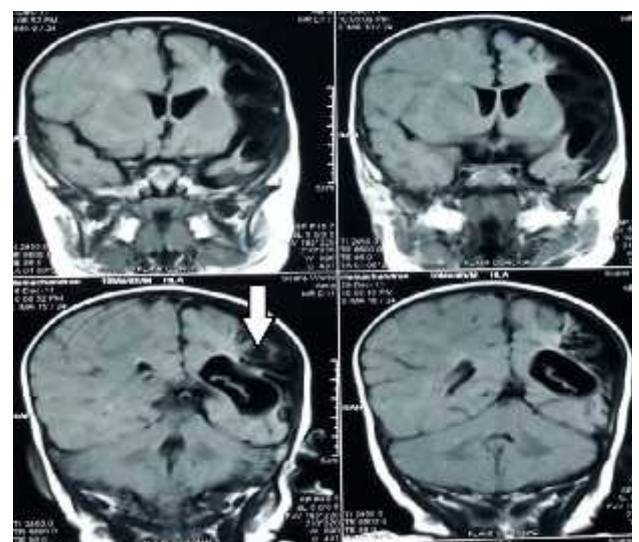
Porencephaly – Coronal FLAIR show old infarct with gliotic change in the left temporo-occipital region
